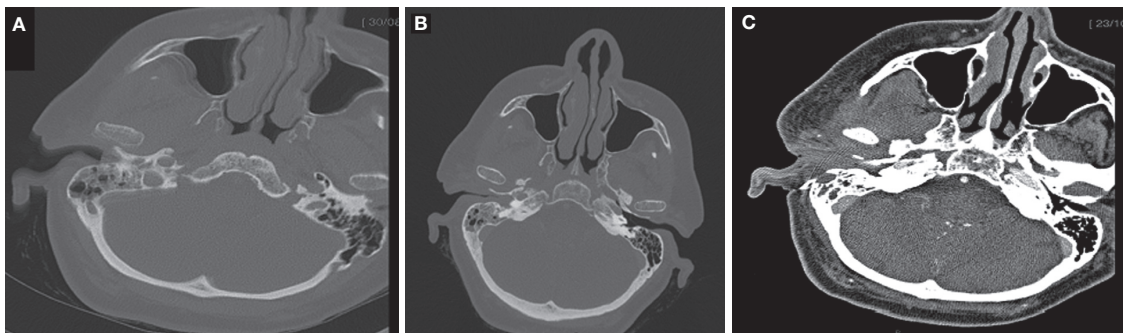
CT scans from patient 3 show external canal swelling and middle ear and mastoid opacification (A), propagation of the infectious process (B), and further deterioration: external canal swelling, middle ear and mastoid opacification, erosion of the mandibular condyle, infratemporal fossa involvement, and parapharyngeal space involvement (C).
